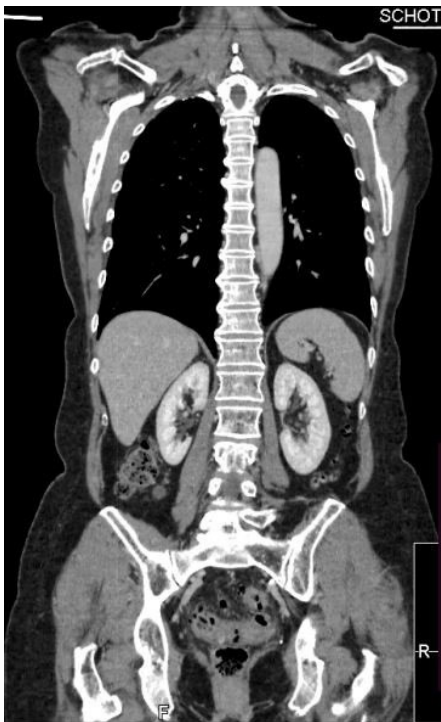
Total Body CT. No neoplastic lesions observed.
